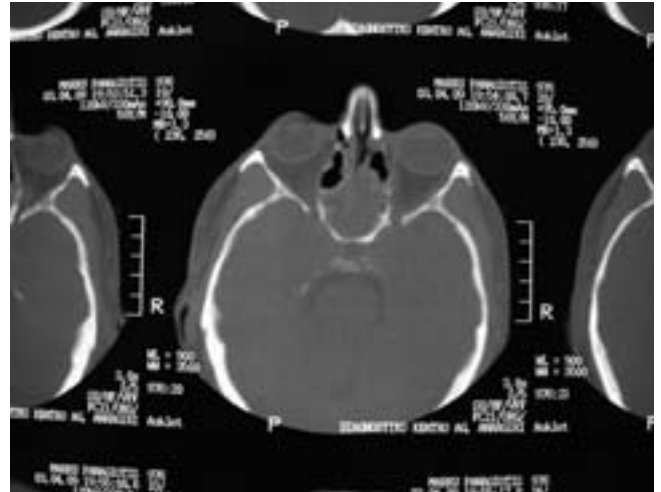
Axial CT view showing the sphenoid sinus of patient case No 3 completely occupied by the opacifying tumor.
